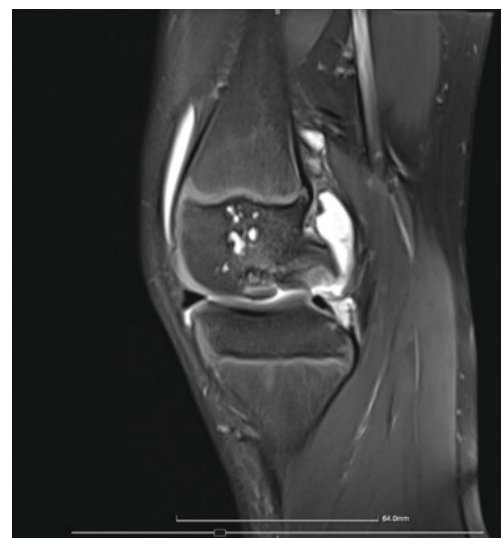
MRI (STIR sequence, sagittal) of the right knee, displaying the fountain-like morphology of the femoral condyle deep to the osteochondral defect in the medial femoral condyle.
